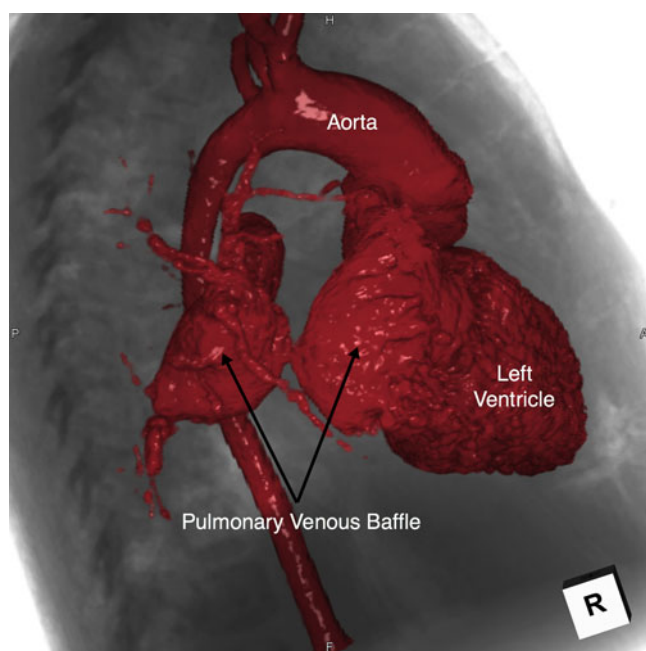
This endocast reconstruction overlaid on a fluoroscopic-appearing image both reconstructed from the cardiac computed tomographic dataset visualises the severe pulmonary venous baffle narrowing in a right anterior oblique projection. The pulmonary veins are visualised to drain into a dilated pulmonary venous baffle proximal the severe discrete narrowing.
